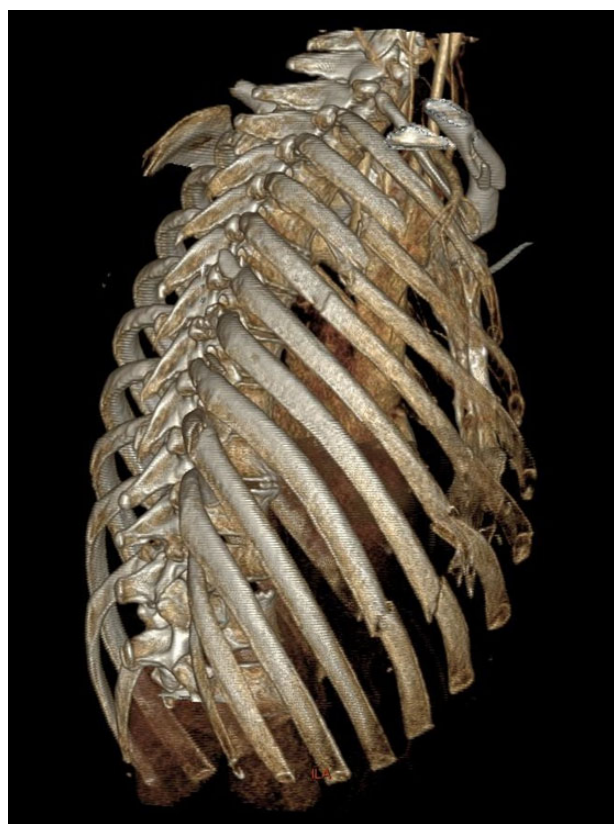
Three-dimensional CT reconstruction showing unilateral fractures to ribs 2–8 on the right, with a flail segment involving ribs 4–8.
